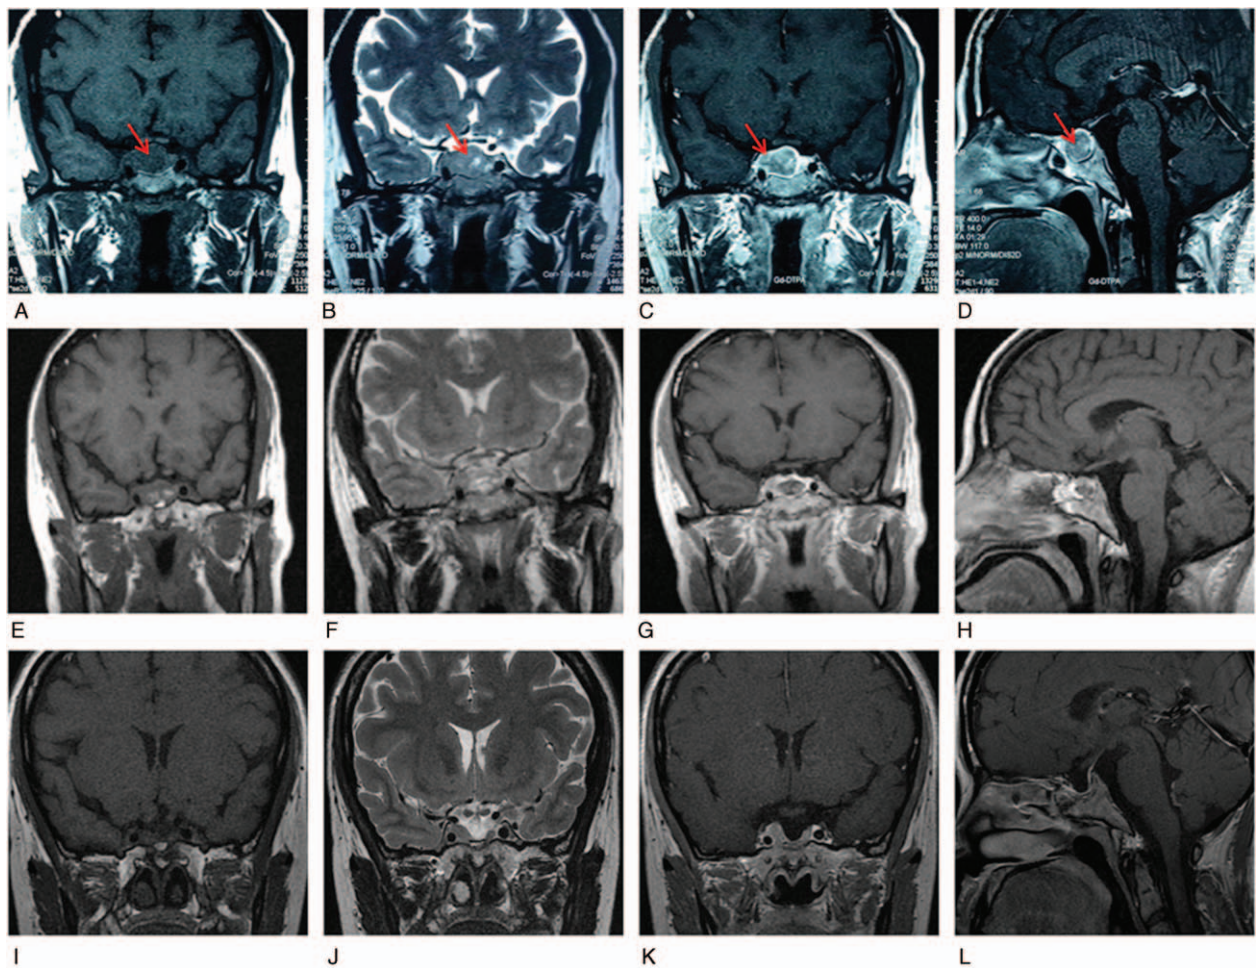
MRI scans of the patient with ganglioglioma. A–D, MRI scan before surgery. T1 weighted image (A) revealed a lesion (arrow head) in the sellar region with hypointense signal; T2 weighted image (B) displayed inhomogeneous hyperintense signal (arrow head); contrast image of coronal plane (C) and sagittal plane (D) showed capsule enhancement (arrow head). E–H, MRI scan within 48 hours after surgery revealed a residual hyperintense signal in sellaturcica without enhancement. I–L, Displayed an empty sella with compressed pituitary devoid of mass and abnormal enhancement. E and I for T1 weighted image; F and J for T2 weighted image; G and K for contrast image of coronal plane; H and L for contrast image of sagittal plane. MRI=magnetic resonance imaging.
